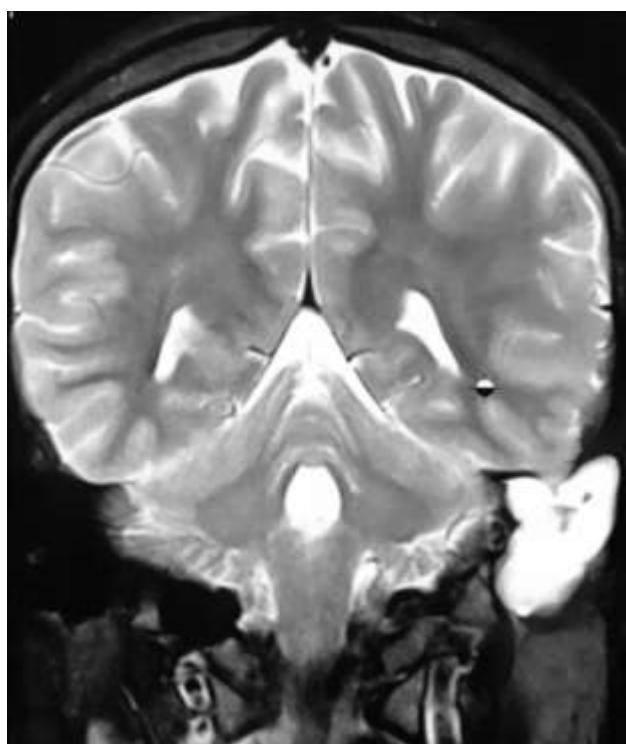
MRI brain with contrast showing the collection on left side
